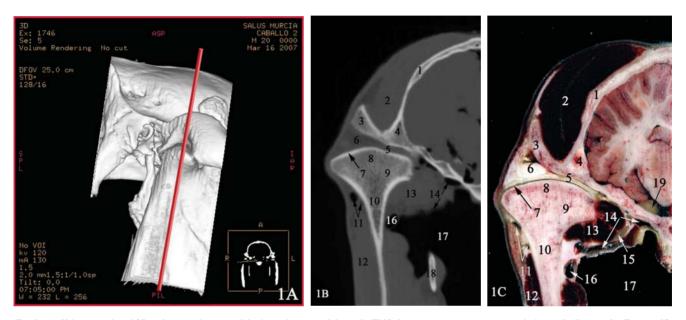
(A) Volume rendered 3D-reformatted image of the lateral aspect of the right TMJ showing a transverse-sectional plane of reference for Figures 1B and 1C; (B) Bone window transverse CT image (window width = 2354; window level= 154) and (C) transverse anatomical section (caudal aspect) of the right TMJ. The progression of CT and anatomical images was from rostral to caudal, from the level of the most rostral aspect of the zygomatic arch. The orientation of CT and anatomic sections is consistent: the right side is to the viewer's left and dorsal is at the top of the image. 1 = parietal bone; 2 = temporal muscle; 3 = zygomatic process of the temporal bone; 4 = squamous part of the temporal bone; 5 = articular disc; 6 = caudal compartment of the dorsal synovial pouch (intra-articular fat tissue); 7 = articular cartilage; 8 = subchondral bone; 9 = mandibular condyle; 10 = ramus of the mandible (spongy bone); 11 = transverse facial vessels; 12 = masseter muscle; 13 = lateral pterygoid muscle; 14 = pterygoid venous plexus and maxillary artery, 15 = mandibular nerve; 16 = buccal vein; 17 = guttural pouch; 18 = stylohyoid bone; 19 = trigeminal nerve.
